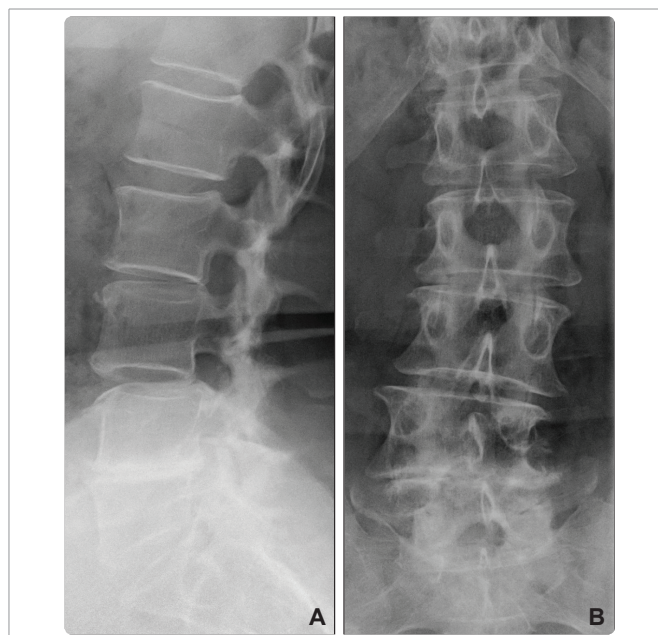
Preoperative X-rays of the lumbar spine in a 76-year-old female patient with low back and leg pain, showing degenerative scoliosis, spondylolisthesis, advanced osteochondrosis with neuroforaminal stenosis, and flattened lordosis in the lumbar spine.
